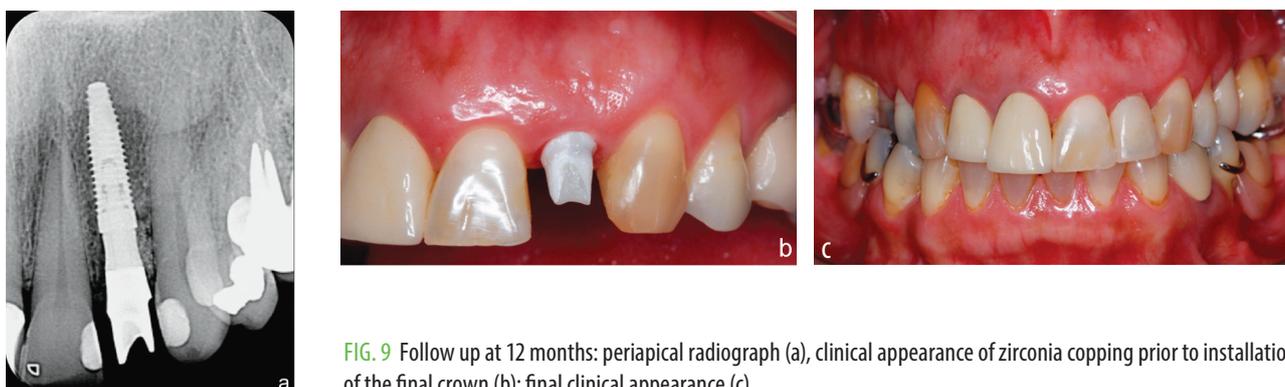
Follow up at 12 months: periapical radiograph (a), clinical appearance of zirconia coping prior to installation of the final crown (b); final clinical appearance (c).
